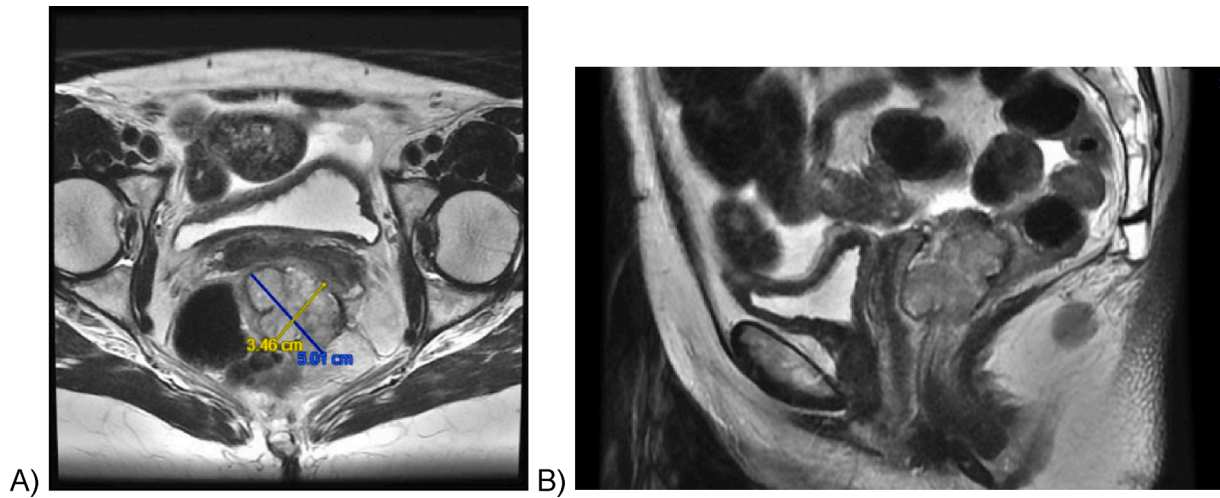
A) Axial View on MRI of the cystic and solid heterogenous mass with interior septations B) Sagittal View on MRI.
